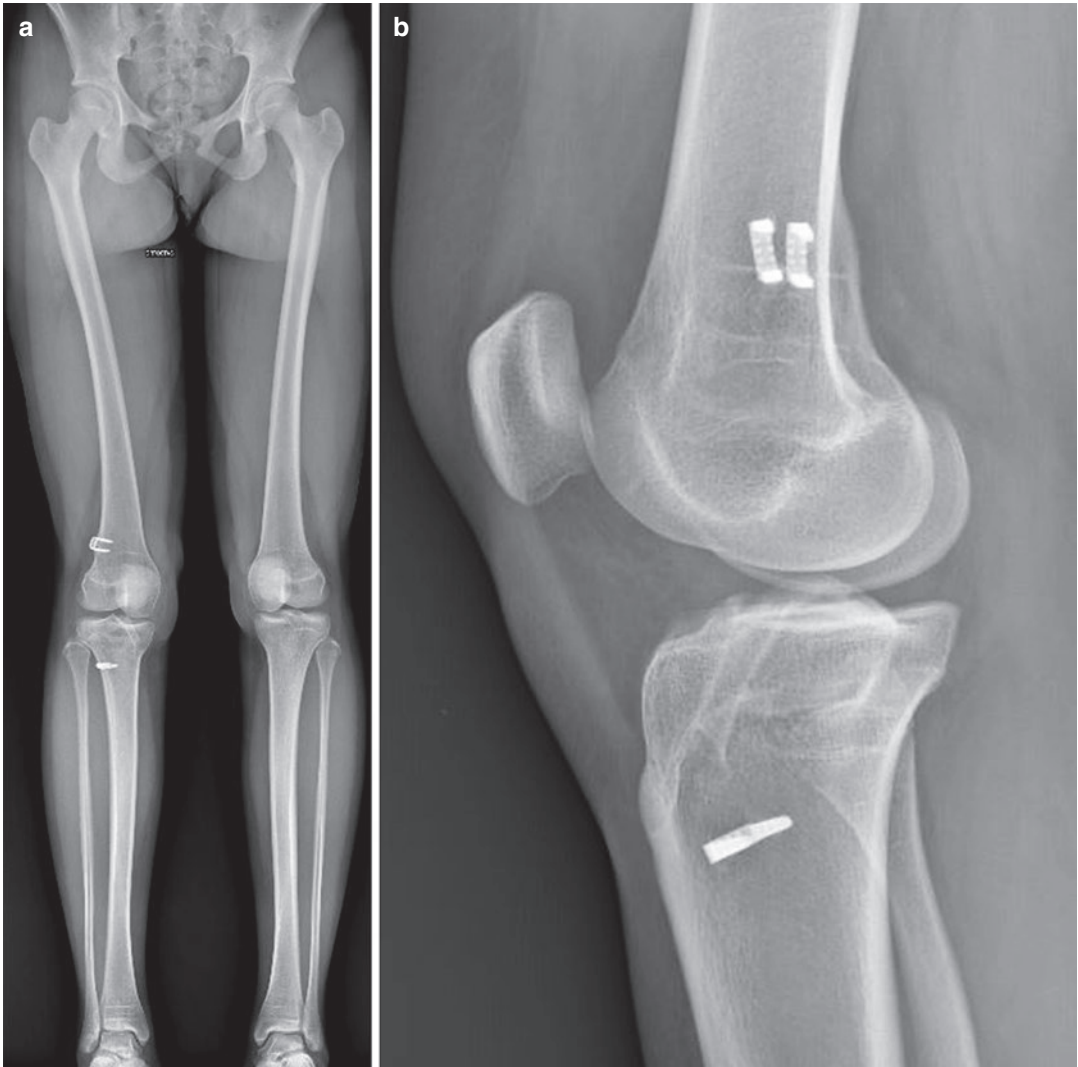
Full standing (a) and lateral (b) X-ray at 4-years postoperative follow-up
